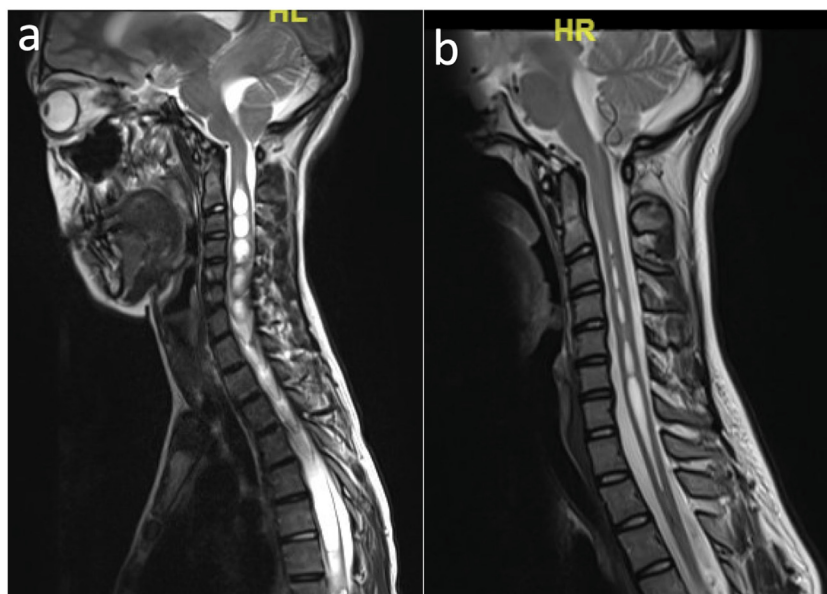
Magnetic Resonance Image (MRI) showing partial resolution of the syrinx after surgery. a) Preoperative sagittal T2 sequence MRI showing tonsillar ectopia and extensive multiloculated syrinx. b) Postoperative sagittal T2 sequence MRI showing improvement of the tonsillar ectopia and partial resolution of the syrinx, especially reduction on the transverse diameter of the syrinx.
